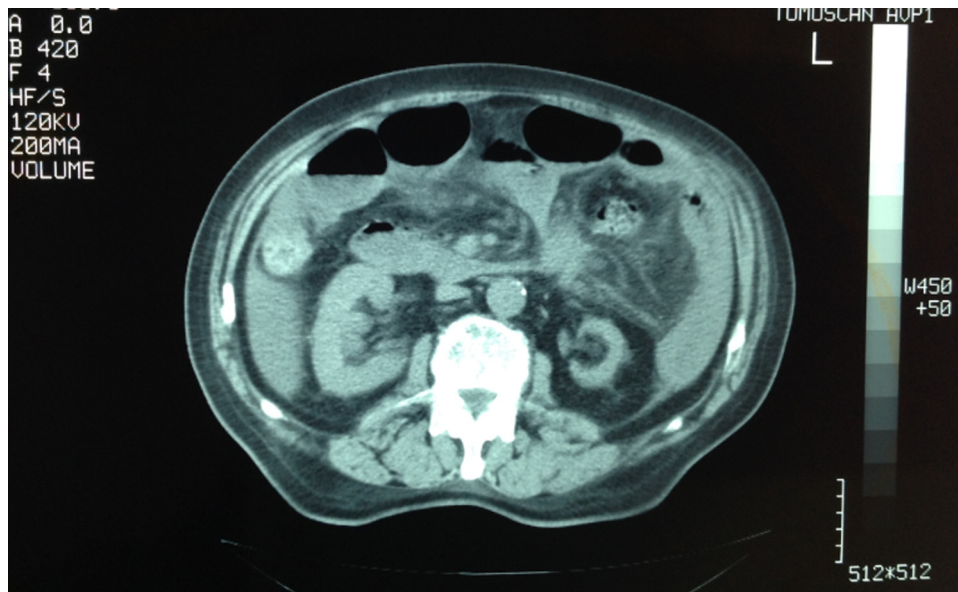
Abdominal CT. Free fluid in the abdominal cavity, turbidity of the mesenteric fat levels, thickening of the small bowel wall, traction of mesenteric helix to suspicious area, and stretching of the bowel central to the pathologic area.
